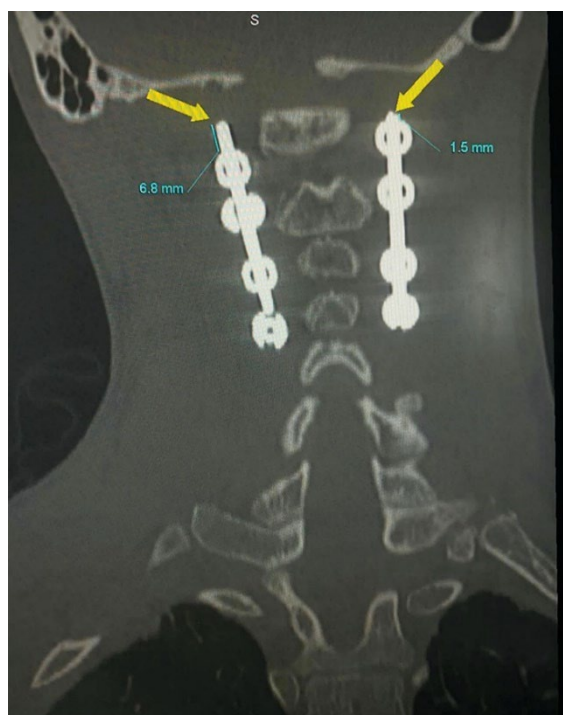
Computed tomography of the cervical spine with malposition of the first locking nut of the upper threaded screw on the right, dislocation of the component part of the metal structure in the direction of the occipital bone up to 6.8 mm
